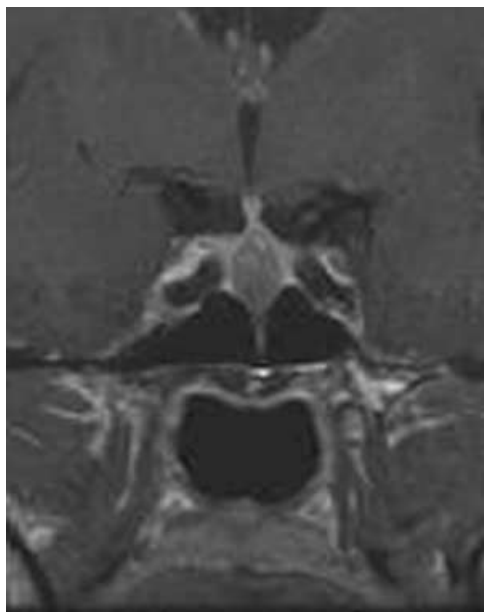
Frontal magnetic resonance image of the sellar region of a 66-year-old female patient with acromegaly. Macroadenoma of the pituitary.
